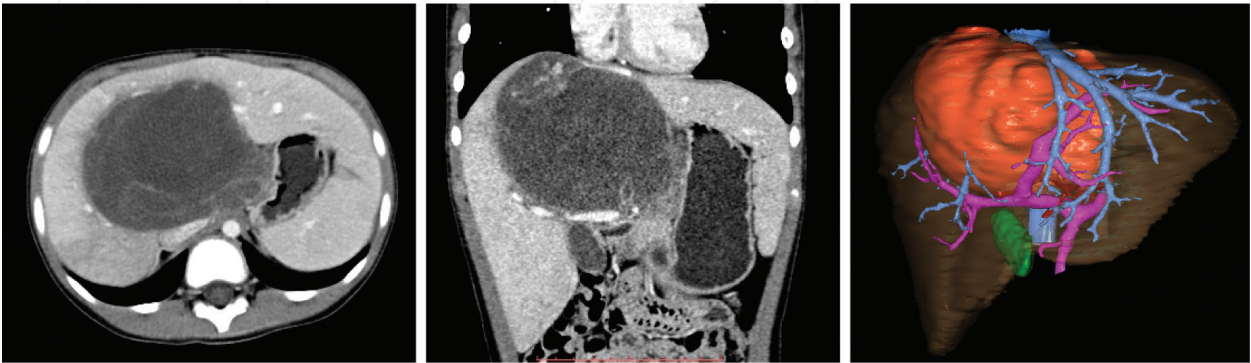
CT and three-dimensional reconstructed liver of undifferentiated embryonal sarcoma.
